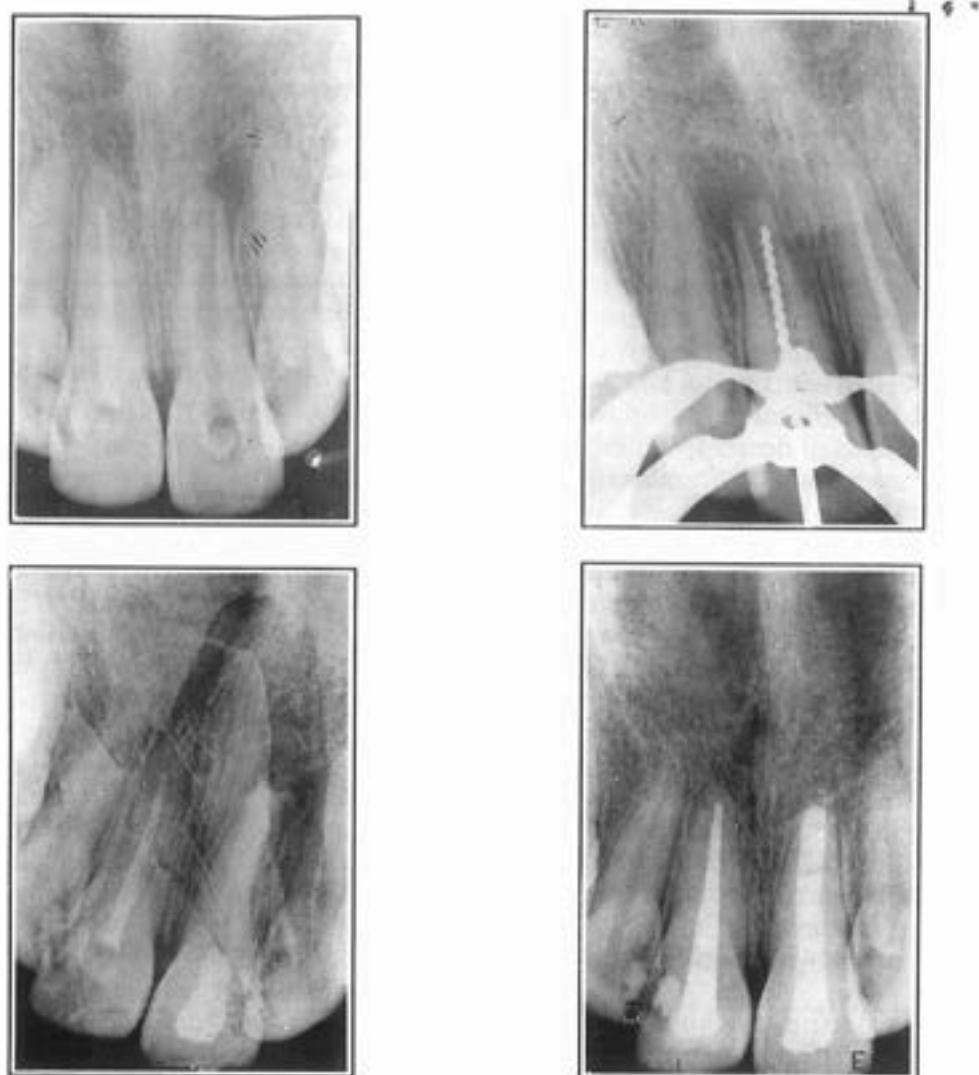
A, Initial x-ray of case 1. B, X-ray showing incomplete root formation with parallel walls. C, Root canal filled with calcium hydroxide paste. D, X-ray 18 months after final obturation.*
